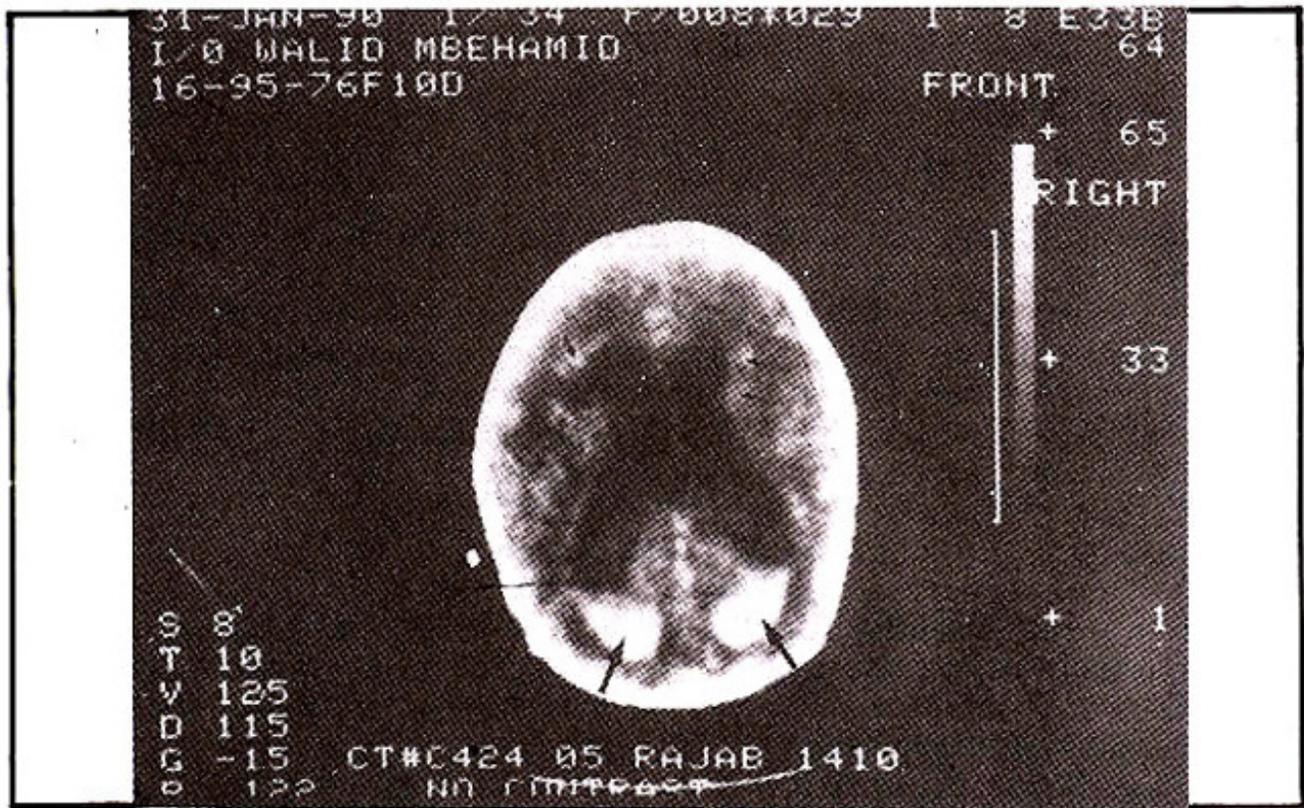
CT scan second case showing marked PHH. Note (i) GMH (small arrows); (ii) IVH (large arrows).
